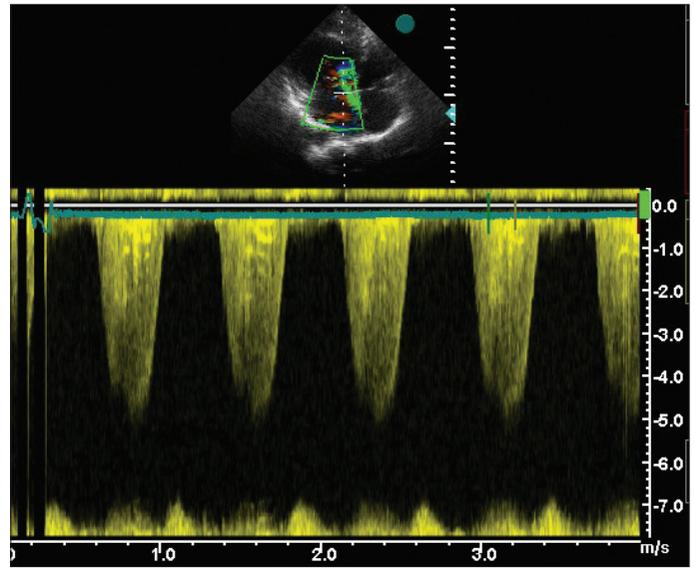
Transthoracic and Doppler echocardiography views of congenitally corrected transposition of the great arteries with ventricular septal defect with left to right shunt
